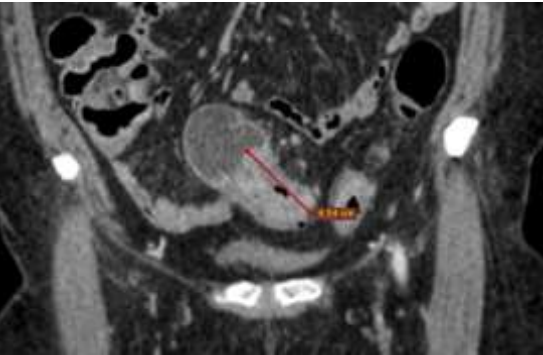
Coronal post contrast CT image showed short segment of irregular circumferential sigmoid colon mural thickening suggestive of sigmoid cancer.
